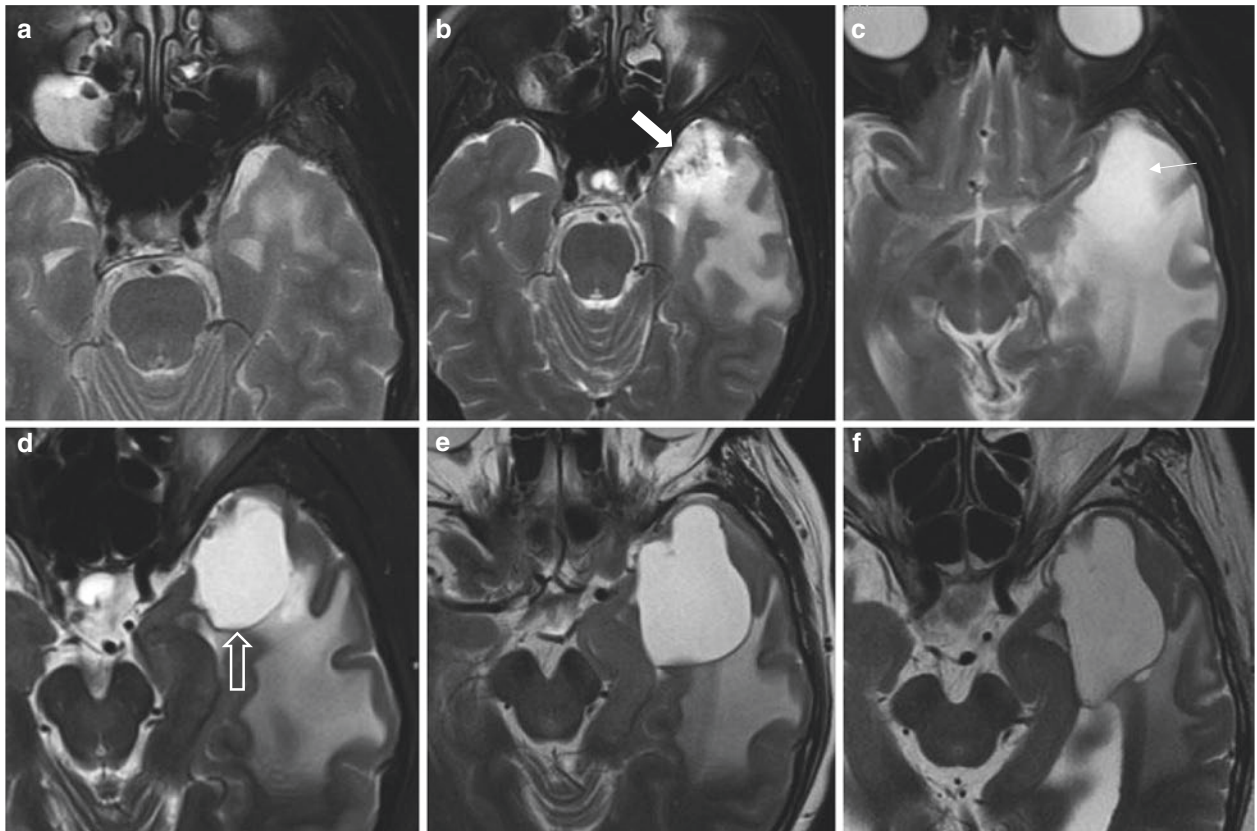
Radiation-induced delayed cyst formation. (a–d) Axial T2 fat saturated and (e, f) Axial T2 images showing development of a tumefactive cyst over the course of 4 years post RT. (a) Early demyelination and oedema with (b) a focus of radiation necrosis (solid arrow) and (c) subsequent enlargement of a liquefied T2 hyperintense area (thin arrow) and oedema. (d–f) Follow-up MRI showed formation of a tumefactive cyst (open arrow) which continued to grow over 2 years
